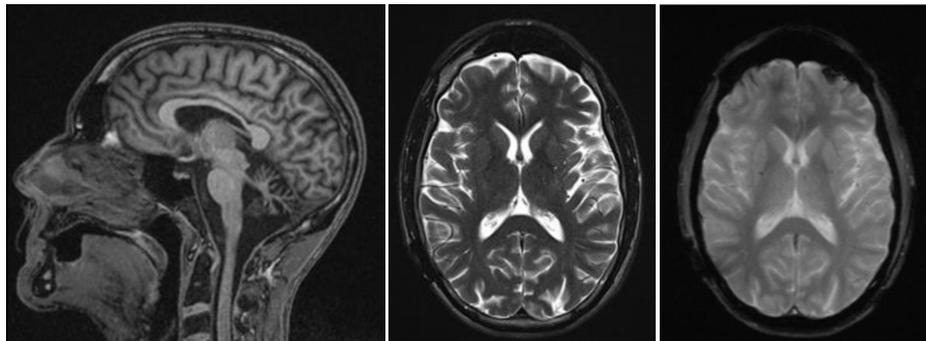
From left to right - Sagittal FLAIR showing marked vermian and ponto-mesencephalic atrophy, no abnormalities in the basal ganglia observed in axial T2 sequences, no iron deposits in the basal ganglia (axial gradient echo).
